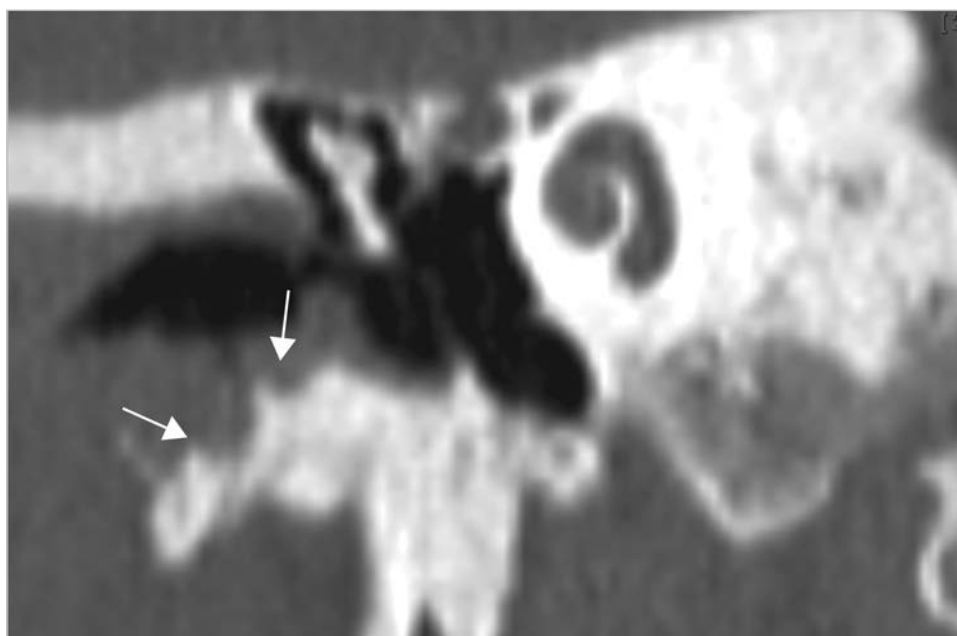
A case of cholesteatoma in the external auditory canal. The coronal CT shows heavy erosion of the tympanic bone (arrows).
